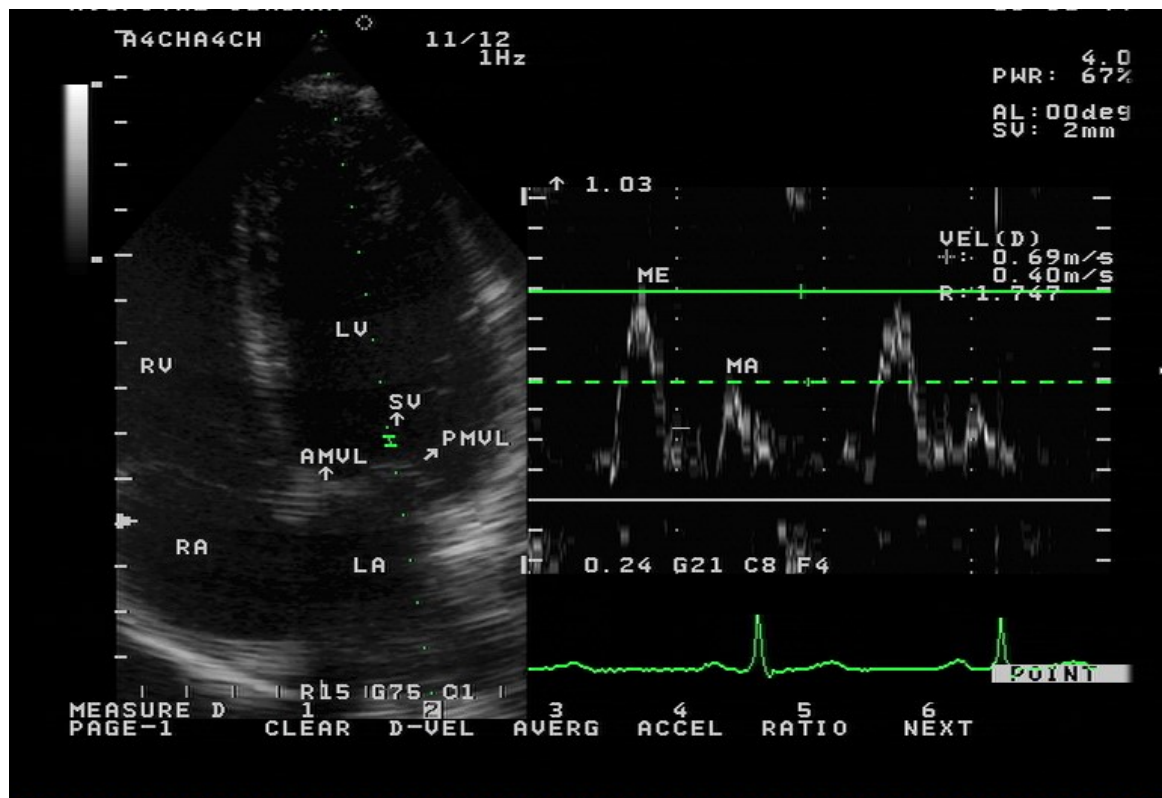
Echocardiogram Showing Measurement of Transmitral Flow Velocity Profile ('E' and 'A' Waves). RV =Right Ventricle, LV=Left Ventricle, RA=Right Atrium, LA =Left Atrium, SV=Sample Volume, AMVL=Anterior Mitral Valve Leaflet, PMVL=Posterior Mitral Valve Leaflet, ME=Mitral E wave, MA=Mitral A wave
